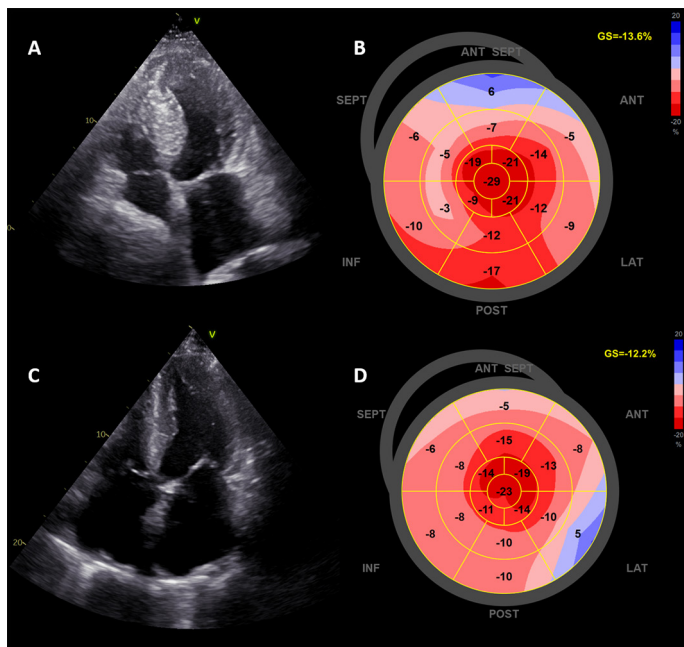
Left ventricular global longitudinal strain to differentiate between mutation-positive sarcomeric hypertrophic cardiomyopathy and cardiac amyloidosis. (A) Apical four-chamber view of a 66-year-old patient known with mutation-positive hypertrophic cardiomyopathy. The thickness of the septum was 28 mm and the left ventricular ejection fraction was 55%. (B) The polar map shows markedly impaired longitudinal strain in the septal mid and basal areas and the global longitudinal strain is impaired (−13.6%). (C) Apical four-chamber view of a 75-year-old patient diagnosed with light chain amyloidosis. There is concentric hypertrophy of the left ventricle and the ejection fraction is 56%. Based on speckle tracking echocardiography analysis, the left ventricular global longitudinal strain is impaired (−12.2%), with typical sparing of the longitudinal strain values in the apical segments (D). ANT, anterior; ANT SEPT, anteroseptal; GS, global strain; INF, inferior; LAT, lateral; POST, posterior; SEPT, septal.
